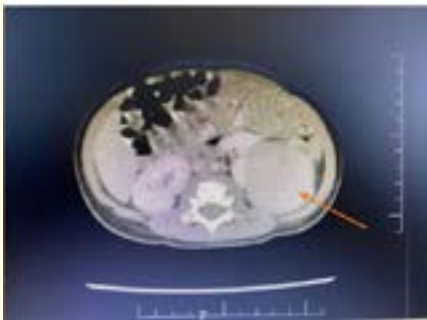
CT image showing left suprarenal mass.
